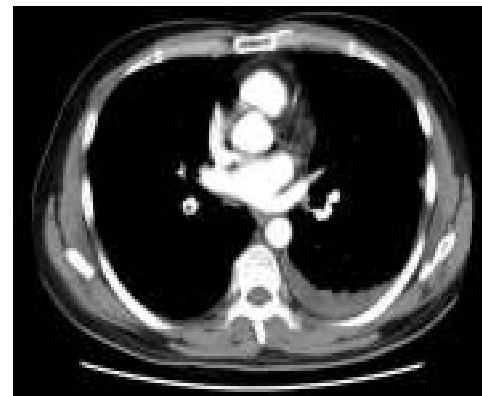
CT Pulmonary angiogram showing right lower lobe pulmonary artery “doughnut” sign (filling defect) suggestive of pulmonary infarct. Along with left pleural effusion and paucity of contrast on left side too.
